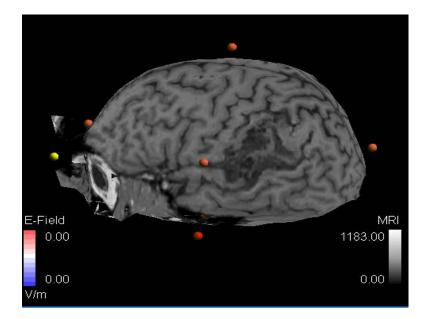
Participant #4 (C.G.) MRI. Findings of the current MRI report showed evidence of extensive low signal intensity involving mainly the cortex and subcortical white matter of the left parietal lobe and extending inferiorly to the level of the left insula. Subtle hypointensity of the deep white matter of the left parietal lobe was also noted.
